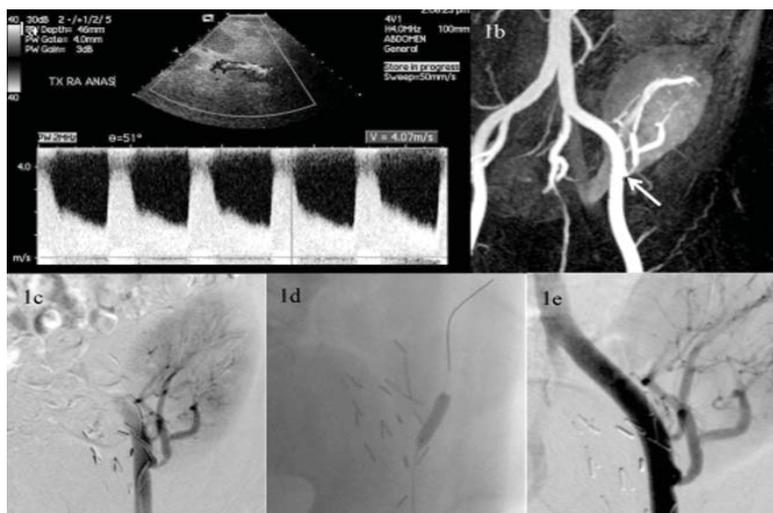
Case of a 50-year-old male with a 1-year-old transplant allograft. (A) Ultrasound doppler showed peak systolic velocity (PSV) of more than 4 m/second of the transplant renal artery. (B) Contrast enhanced MRA confirmed TxRAS at the anastomotic site (arrow). (C) Angiogram via the ipsilateral femoral approach confirmed a 75% TxRAS. (D) PTA performed with 5 mm x 20 mm angioplasty balloon. (E) Post PTA angiogram demonstrated a good result with 20% residual stenosis.
